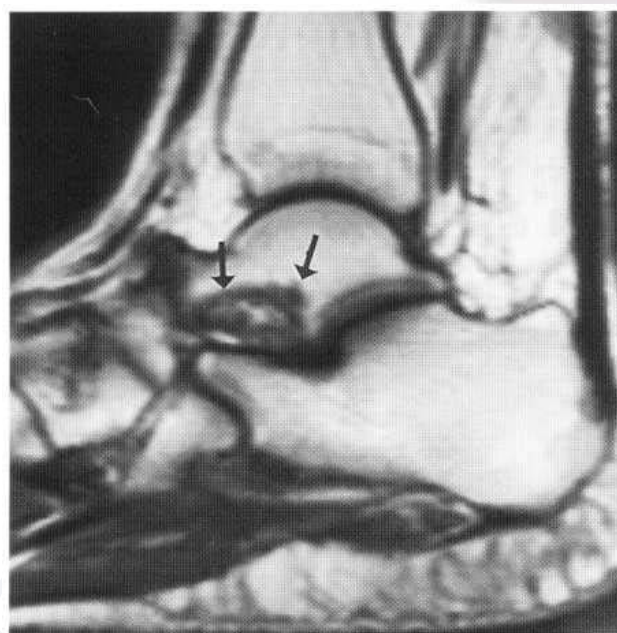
Osteochondral fracture. Sagittal T_1 -weighted MRI of the ankle. There is a well-defined area of abnormal signal in the inferior border of the talus at the insertion of the interosseous ligament (arrows). The ligament itself cannot be seen, indicating disruption.
